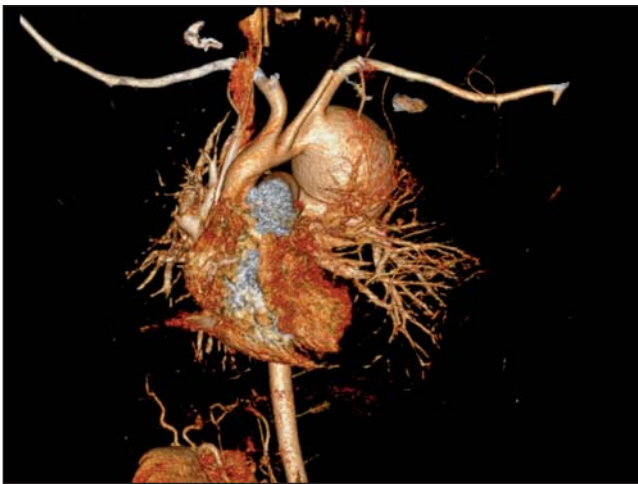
CT reconstruction of aortic aneurysm.
